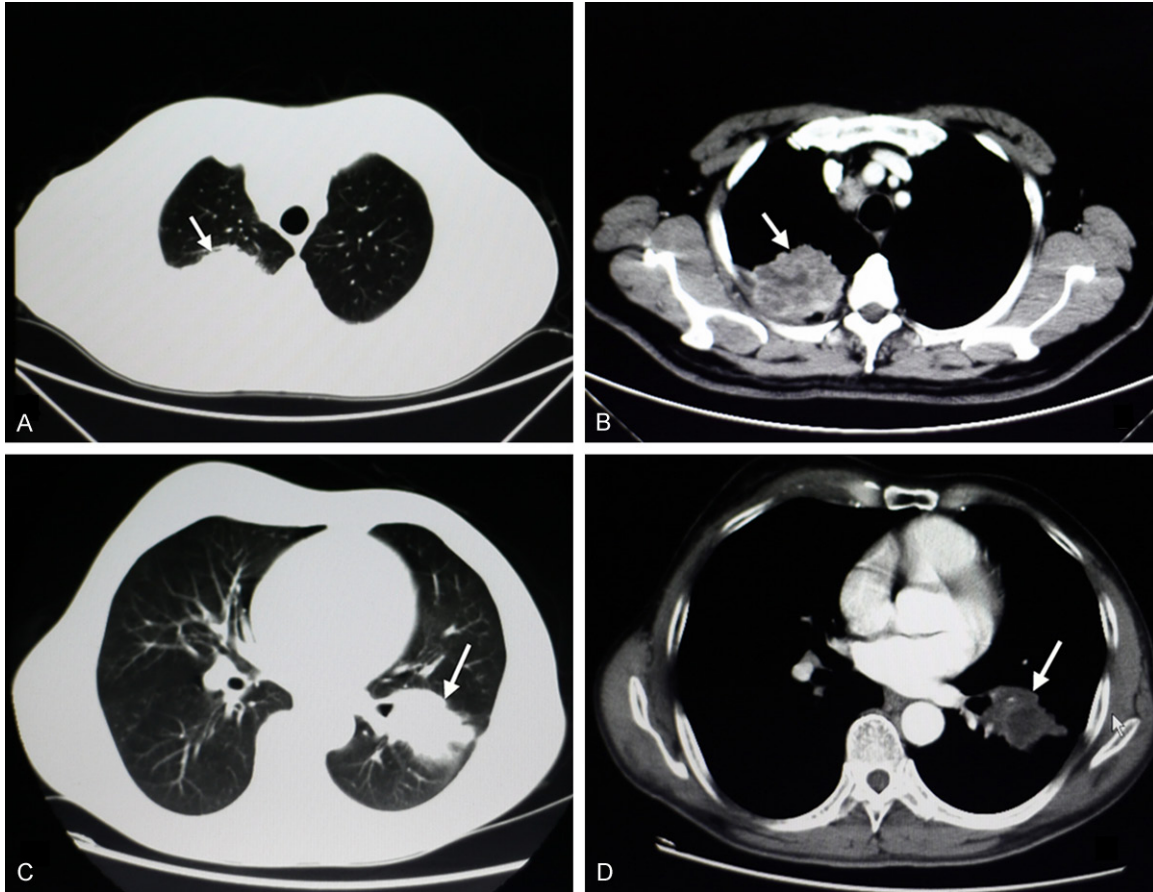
Computed tomography (CT) features. A and B: CT revealed a mass in the right upper lobe of representative case 1 (arrowhead). C and D: CT revealed a mass in the left hilum of representative case 2 (arrowhead).
